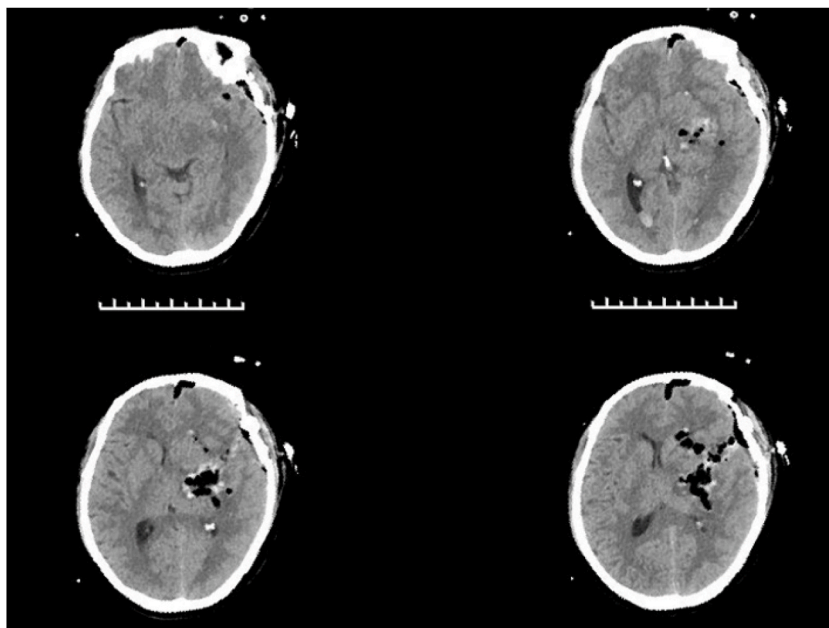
On the first day after operation, CT craniocerebral examination showed postoperative changes.
